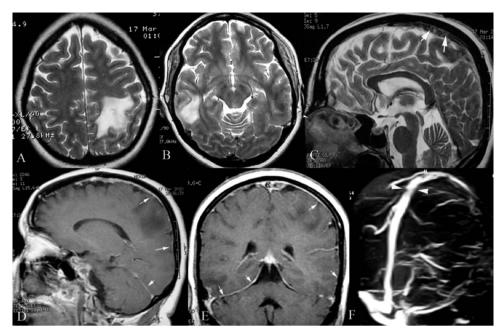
Axial T2-weighted images showing infarcts in the paracentral area of the left parietal lobe at the convexity (A) and in the subcortical area and lateral cortex of the right temporal lobe (B). Sagittal T2-weighted MRI showing a thrombus in the superior sagittal sinus (C, arrows). Sagittal and coronal contrast-enhanced T1-weighted images showing dural thickening and contrast enhancement secondary to the intracranial hypotension syndrome (D and E, arrows). MRV showing thrombosis of the superior sagittal sinus (F, arrowheads).
